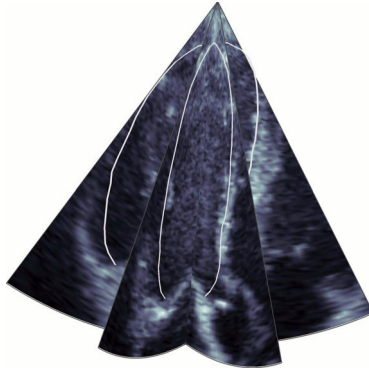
The 3D acquisition configuration for triplane recordings results in three different imaging planes which can be tuned to each patient case, resulting in the standard apical four chamber, two chamber, and long axis views. Examples of detected contours using the Multi View Active Appearance Motion Model are shown as white lines.
